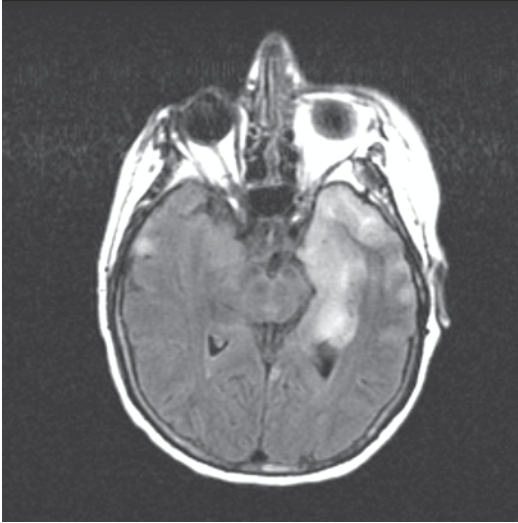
Axial, T2-weighted MRI showing left medial temporal lobe increased signal in a 53-year-old patient with fever and encephalopathy, CSF HSV PCR positive (Courtesy of Dr. Blaine Hart)
